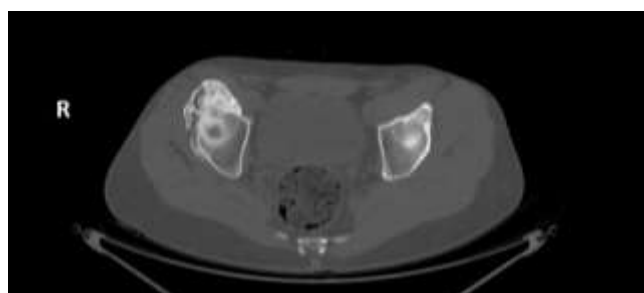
CT scan –Axial Section - 2017 November
